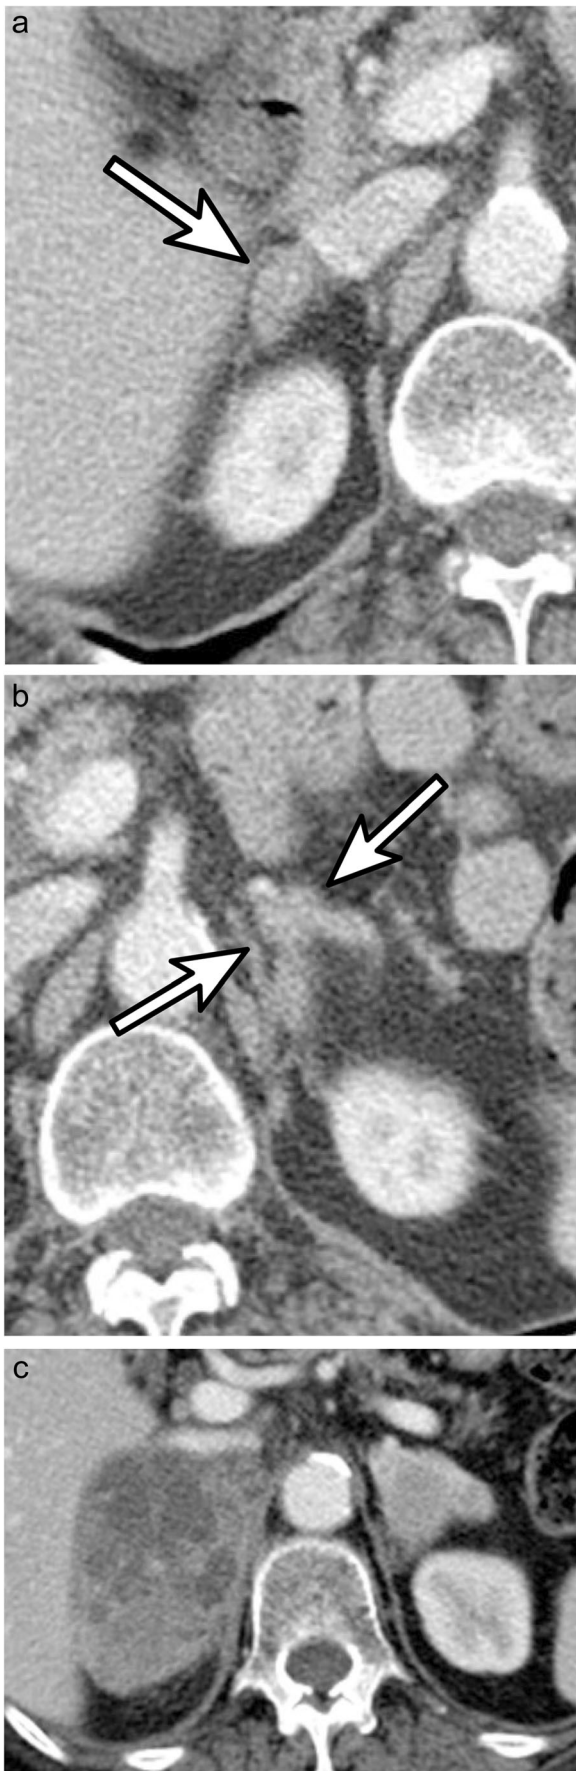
A 78-year-old woman with ascending colon cancer and malignant adrenal nodules. Contrast-enhanced transverse image of staging CT shows (a) a 15-mm nodule (arrow) in the right adrenal gland, and (b) a 12-mm nodule (arrow) in the left adrenal gland. These two nodules and another small nodule in the left gland (not seen in the image) were detected via retrospective CT image review but were omitted from the official CT report. Liver MRI and chest CT performed at the time of staging did not show any sign of other distant metastasis. The patient received right hemicolectomy for the cancer, which was confirmed as pT2N0 stage. (c) Contrast-enhanced transverse image of follow-up CT 6 months after surgery shows bilateral adrenal masses, without any evidence of other metastasis on CT. These nodules were adjudicated as metastases from the ascending colon cancer
